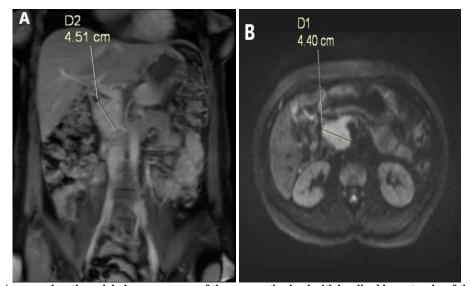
MRI: A- coronal section: globular appearance of the pancreatic gland with localized hypertrophy of the incus. B- Axial section
